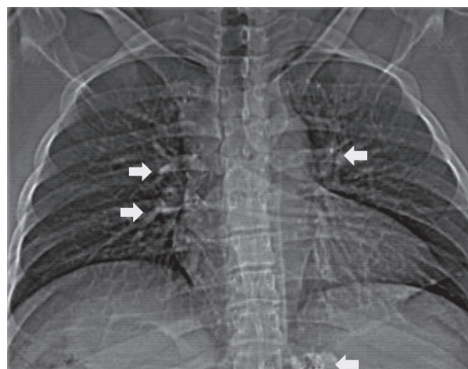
Chest radiograph, following variceal sclerotherapy, showing branching opacities of lipiodol and cyanocrylate mixture throughout both lungs
